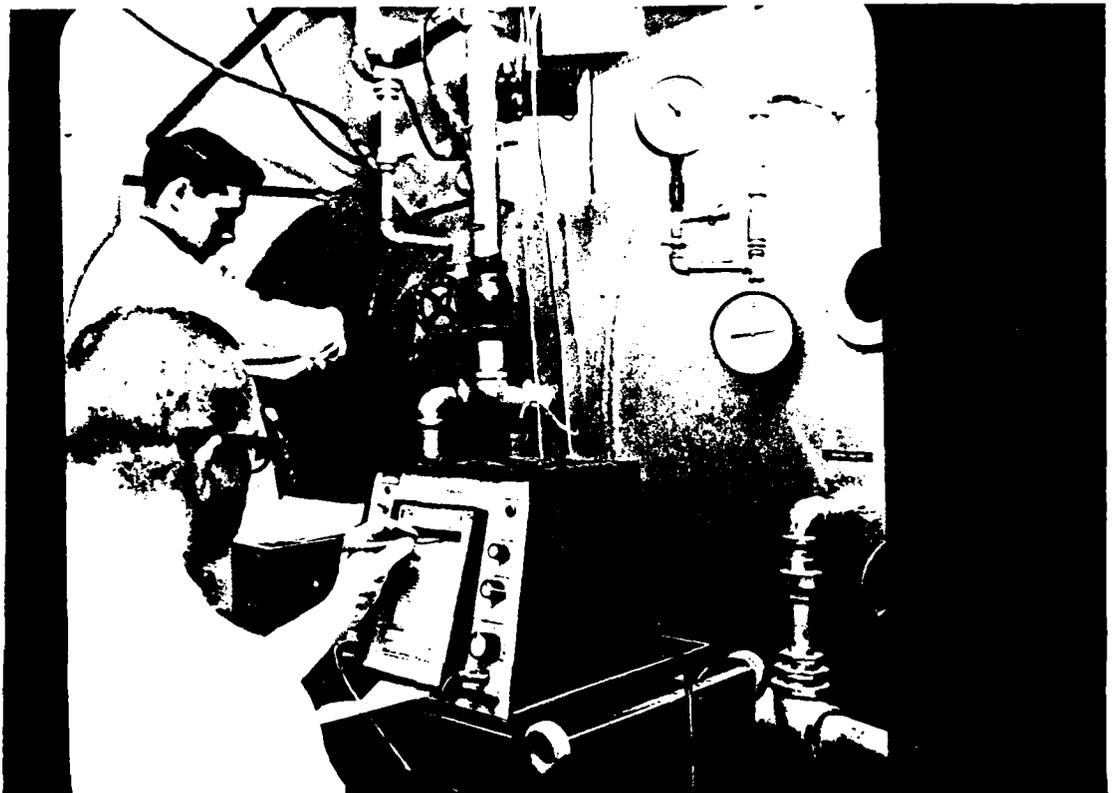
Seattle Lake City Medical Hyperbaric Treatment Lock at the first time of Doppler-detected venous gas emboli, 1967. (Courtesy of Dr. Leon Sealey.)
